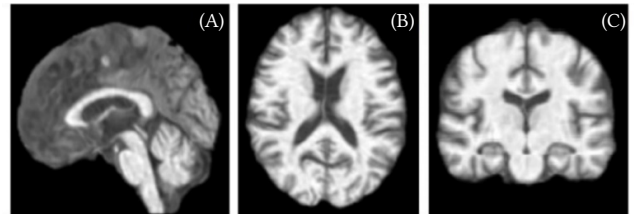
MRI Preprocessed Views; (A) Sagittal Slice, (B) Coronal Slice, and (C) Transverse Slice.
